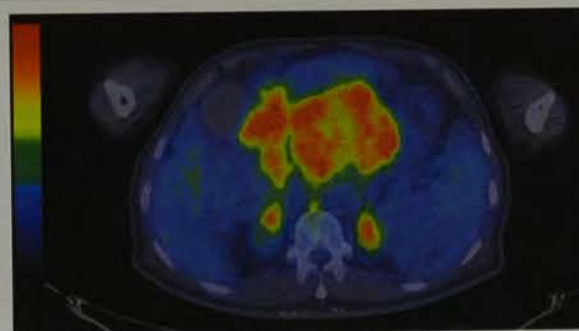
A PET-CT image.
